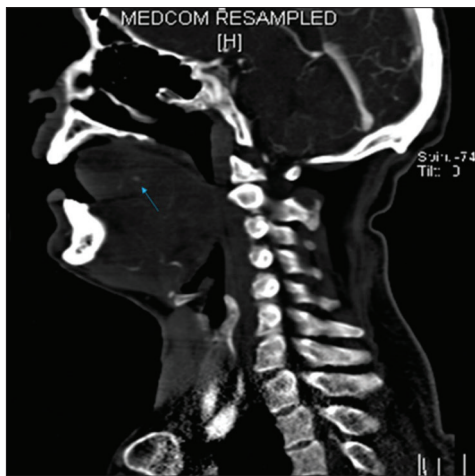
Contrast-enhanced computed tomography face with neck sagittal view showing large swollen tongue with contrast extravasation from the right lingual artery (blue arrow)
